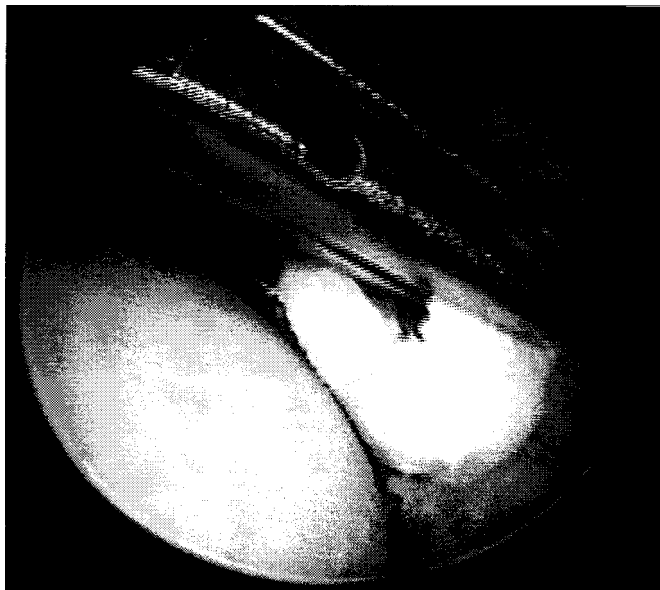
Typical cartilaginous loose body that might be found even if preoperative radiographs show a concentric reduction with no osseous loose bodies. This loose body came from delaminated cartilage bordering a posterior wall fracture.
